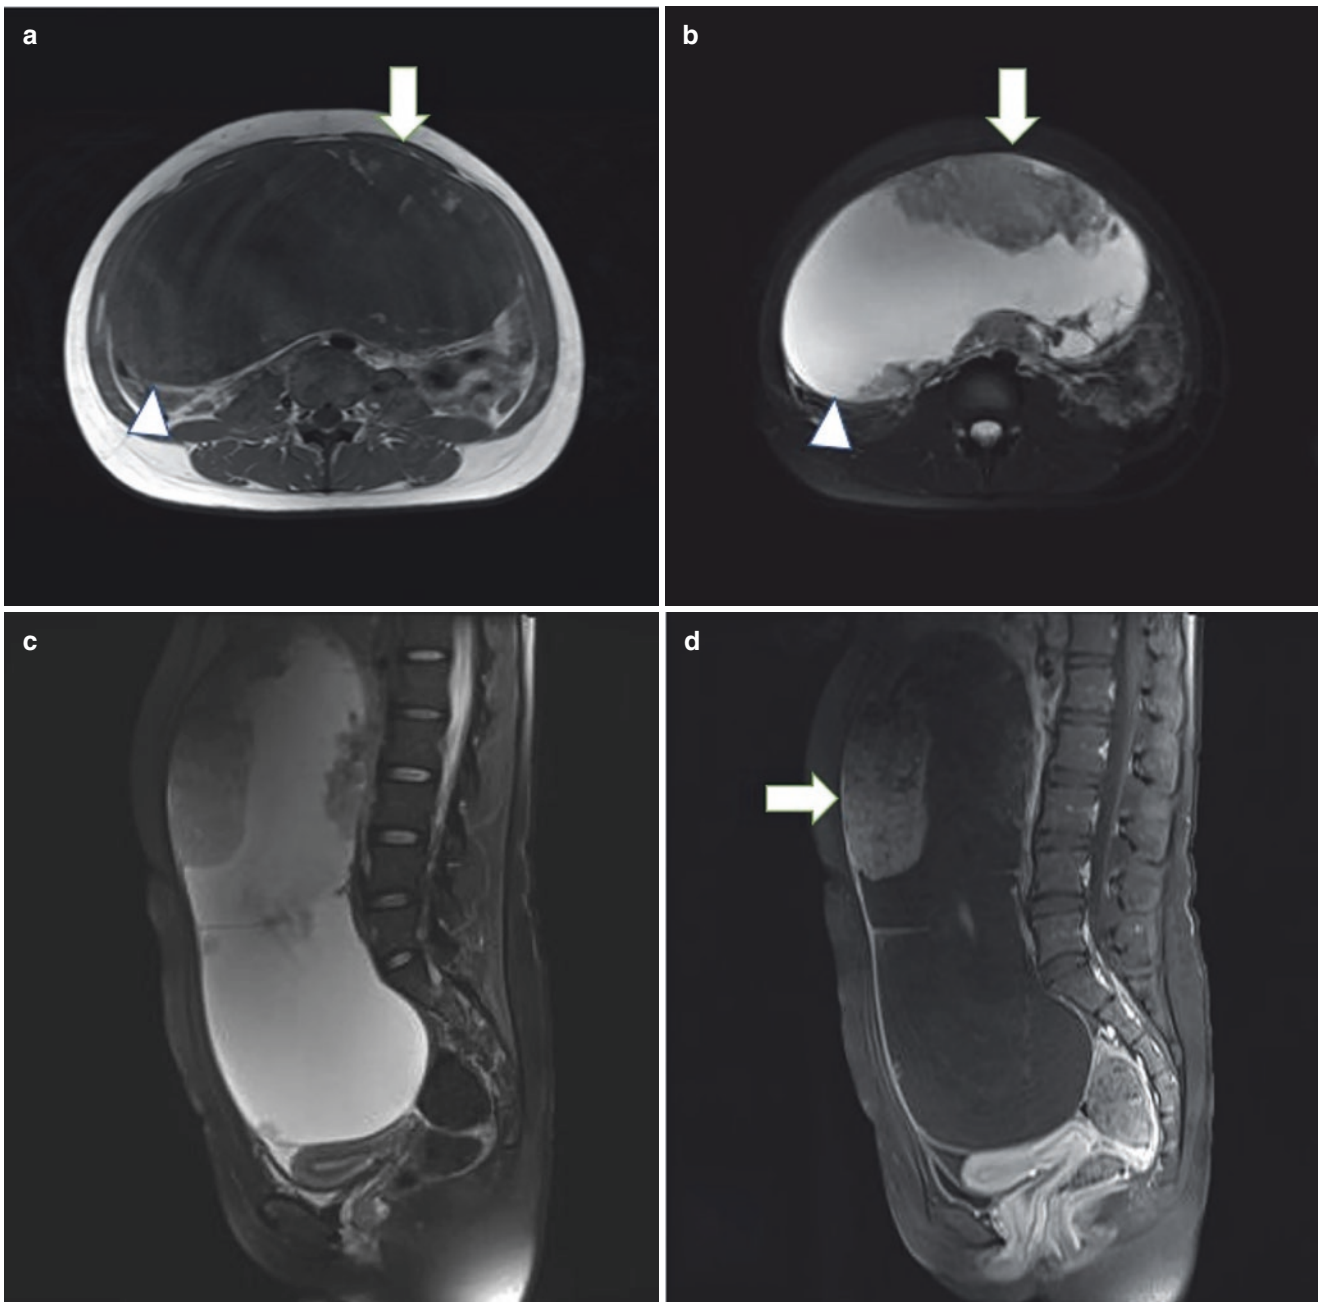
A 20-year-old woman. She complained of abdominal distension, vomiting, diarrhea, and an increase in abdominal girth. CT (the outer hospital) displayed a mass with an average density of 15–28 Hu. Within the mass, there was a patchy of calcification and a strand of low-density components. A month after the CT examination, she underwent an MRI examination. The final pathological diagnosis was ovarian
